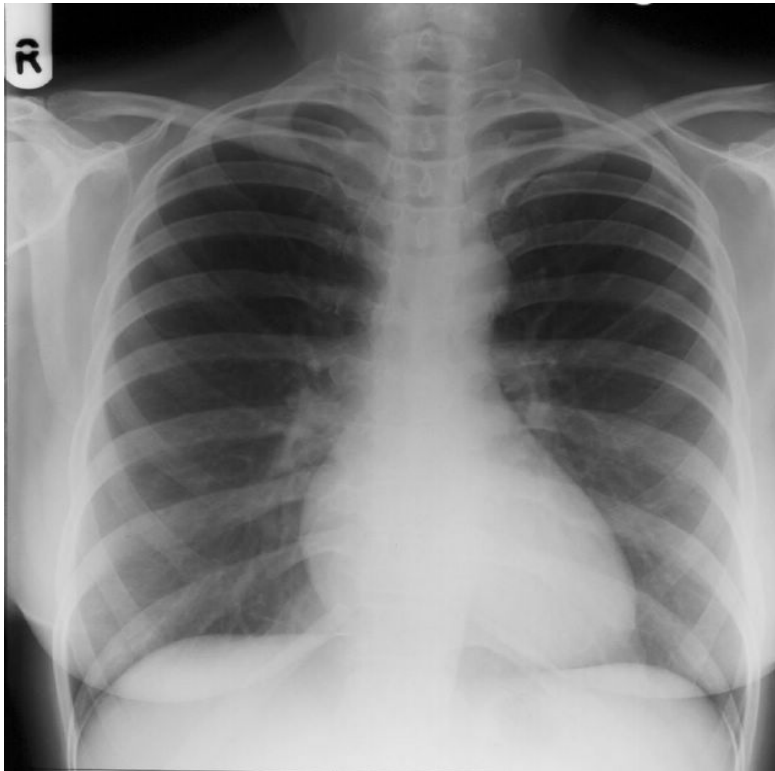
Chest radiograph. Posterior-anterior projection.
